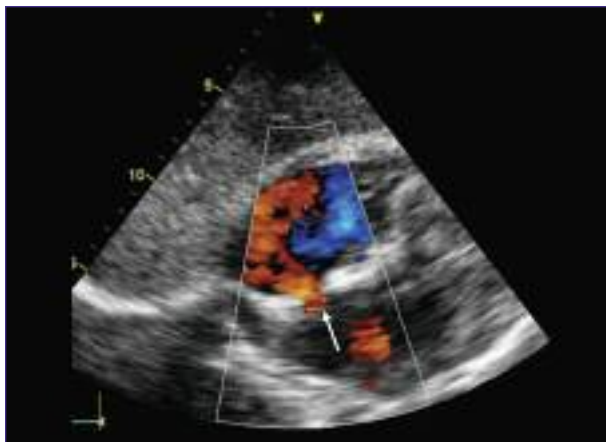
A subxiphoid view on transthoracic ECHO demonstrating left to right shunting across the interatrial septum on colour Doppler.
